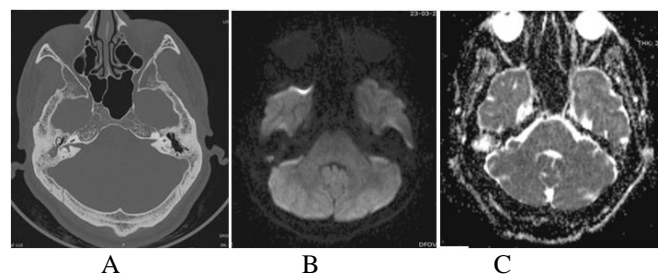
A 39 year old male presented with ear pain, discharge and hearing loss on right side. HRCT temporal bone (a) showed soft tissue content in epitympanum and mastoid with erosions of scutum. Corresponding area does not show diffusion restriction with low signal on DWI (b) and high signal on ADC (c) indicating non cholesteatomatous CSOM.
